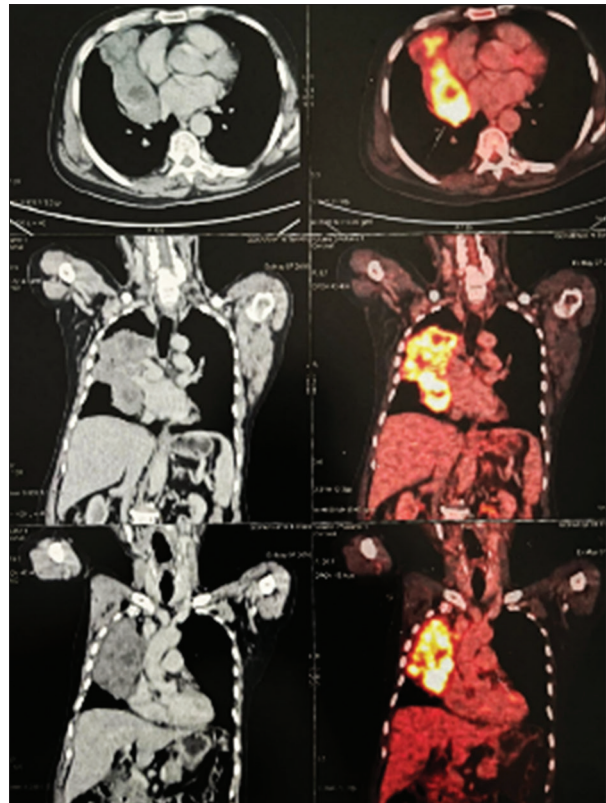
Baseline positron emission tomography-computed tomography shows metabolically active mass ($10 \times 8 \times 13$ cm; SUV-17.23) and low-grade activity in mediastinal/hilar nodes (largest 1.8 cm SUV_{max}-3.65)
